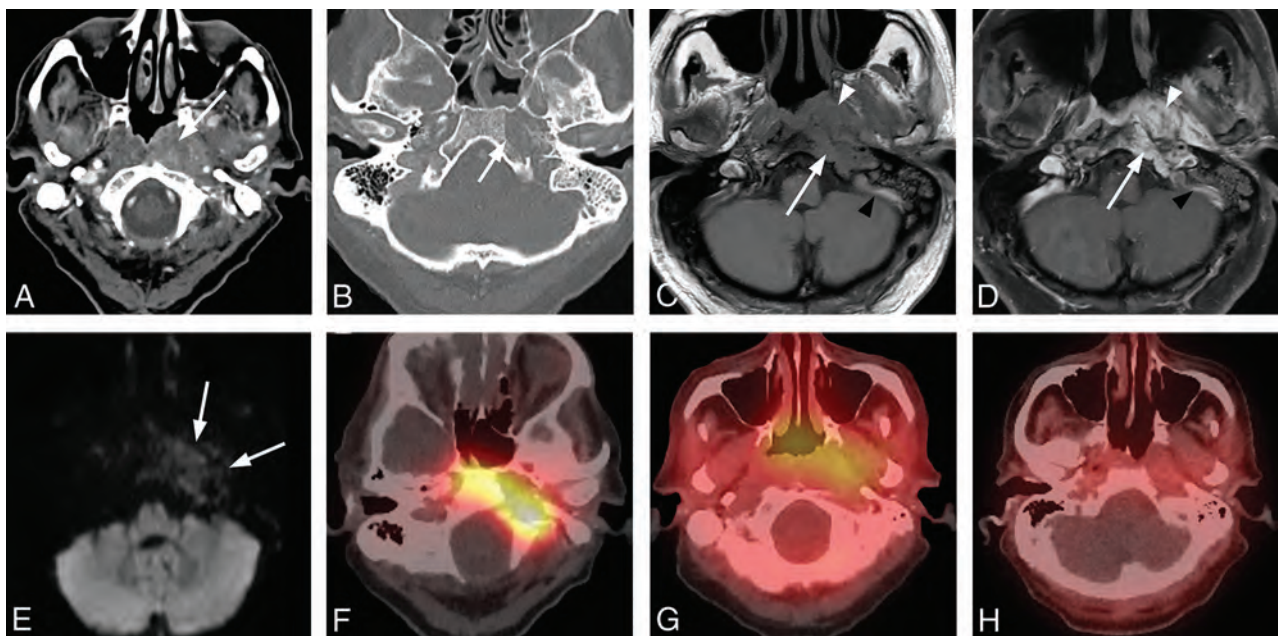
Typical skull base osteomyelitis. A 63-year-old man with diabetes presented to an outside hospital with a several-month history of left ear pain. He was initially diagnosed with otitis media and treated with several rounds of antibiotics. A recent evaluation at an outside hospital suggested the presence of a nasopharyngeal mass with skull base invasion. Two separate biopsies of the nasopharynx failed to demonstrate nasopharyngeal carcinoma. While a discrete organism was not cultured, the patient was presumptively treated with levofloxacin and clindamycin with gradual improvement and resolution of all symptoms. He was monitored using serial CT, MR imaging, and gallium scans. A, Axial postcontrast CT of the soft tissue of the neck at the level of the nasopharynx demonstrates a heterogeneously enhancing soft-tissue lesion involving the submucosal region of the left nasopharynx (arrow). The process extends laterally to the left carotid space, and there is occlusion or thrombosis of the left internal jugular vein. B, Axial postcontrast CT scan through the skull base with bone windows demonstrates focal cortical erosion along the margins of the foramen lacerum (arrow), consistent with osteomyelitis. C, Axial T1-weighted MR image through the skull base shows an infiltrative process involving the left side of the clivus (arrow) and adjacent preclival tissues of the left nasopharynx. The lesion appears masslike on the left (arrowhead). The infiltrative process extends posterolaterally on the left to the jugular foramen. Partial thrombosis of the jugular bulb and sigmoid sinus is identified (black arrowhead). D, Axial enhanced T1-weighted MR image through the skull base shows an enhancing infiltrative process involving the left side of the clivus (arrow) and adjacent preclival tissues of the left nasopharynx (arrowhead). The process extends posterolaterally on the left to the jugular foramen. Partial thrombosis of the jugular bulb and sigmoid sinus is identified (black arrowhead). E, Axial DWI shows no diffusion restriction in the nasopharyngeal soft tissue, favoring a non-neoplastic process over lymphoma or nasopharyngeal carcinoma. F, Axial fused Tc99m MDP bone scan SPECT image shows localized accumulation of radiotracer in the left skull base, compatible with osteomyelitis. G, An axial fused gallium scan SPECT image at the level of the nasopharynx shows mild uptake in the soft tissues of the nasopharynx. H, A follow-up fused gallium scan SPECT image at the level of the nasopharynx demonstrates resolution of previously seen uptake in the nasopharyngeal soft tissues, favoring a treatment response.
